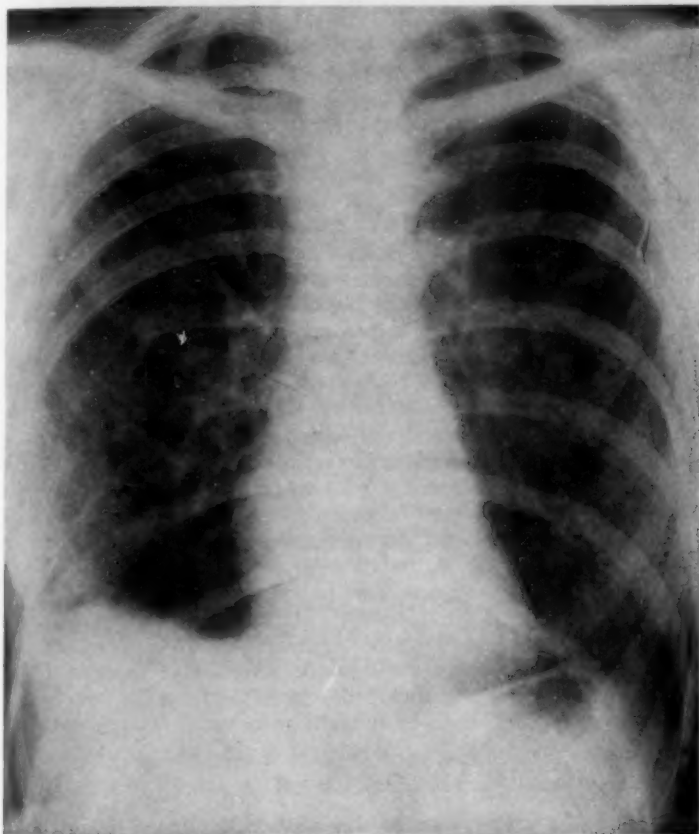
Roentgenogram of lungs taken four months after operation. Complete healing of the abscess cavity has occurred. The right diaphragm is slightly elevated and adherent to the lateral chest wall. There is pleural thickening along the lateral chest wall on the right and increased markings in the right midlung field. The eighth and ninth ribs are partially resected.
